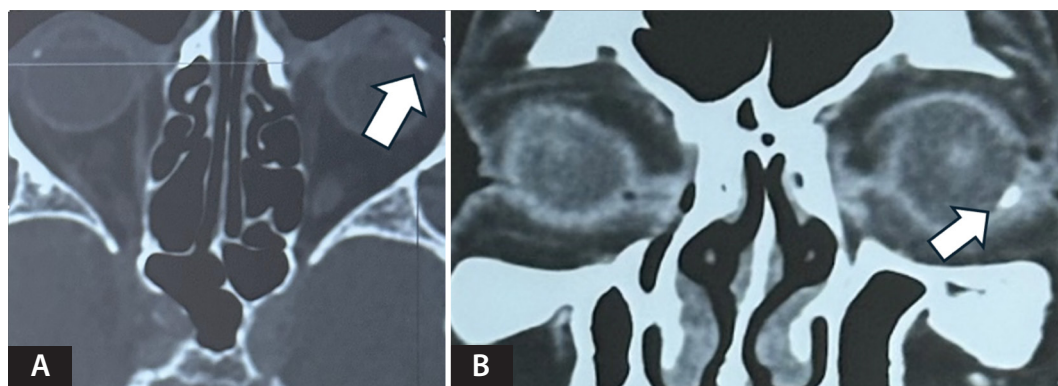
Computed tomography of the orbits and brain showing inferior temporal calcification in both views. A) Bone view in the axial section. B) Soft-tissue view in the coronal section.
